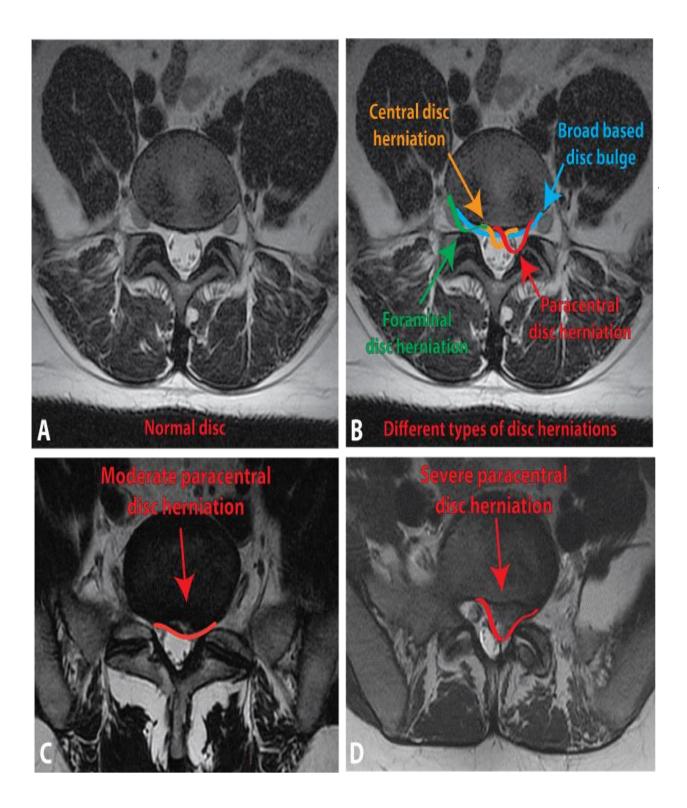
MRI showing various disc disorder in axial view
